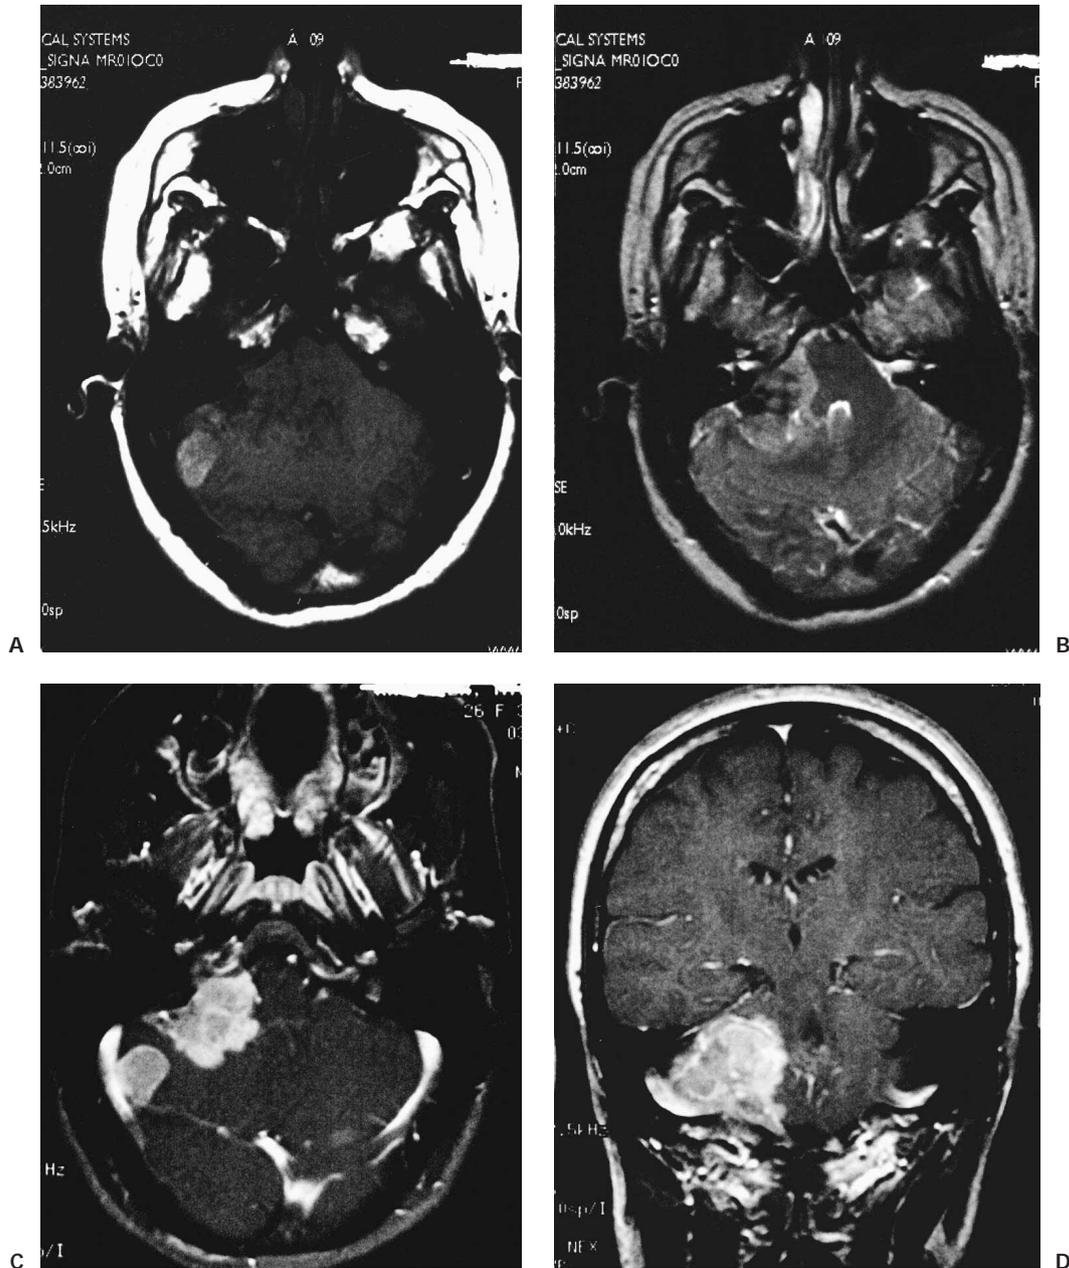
(A) Axial T1-weighted image, (B) axial T2-weighted image, (C) axial T1-weighted image with gadolinium, and (D) coronal T1-weighted image with gadolinium show an extra-axial mass of the right CPA. A dural tail extends into the internal auditory canal, jugular foramen, and hypoglossal canal. The lesion, $3.4 \times 2.3 \times 2.5$ cm, exerted mass effect on the midbrain. It was hyperintense on T1-weighted images and isointense on T2-weighted images with a homogeneous appearance. After gadolinium administration it enhanced prominently. A second smaller dural-based lesion was found in the lateral aspect of the right posterior fossa, invaginating into the adjacent cerebellum.
